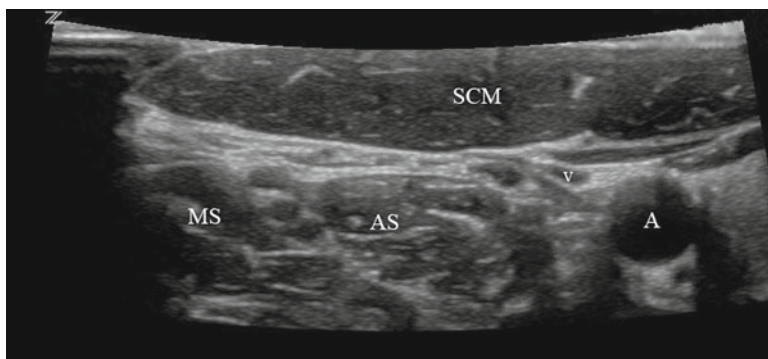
Ultrasonographic appearance of the interscalene and cervical paravertebral brachial plexus (A carotid artery, AS anterior scalene muscle, MS middle scalene muscle, SCM sternocleidomastoid muscle, V internal jugular vein)
